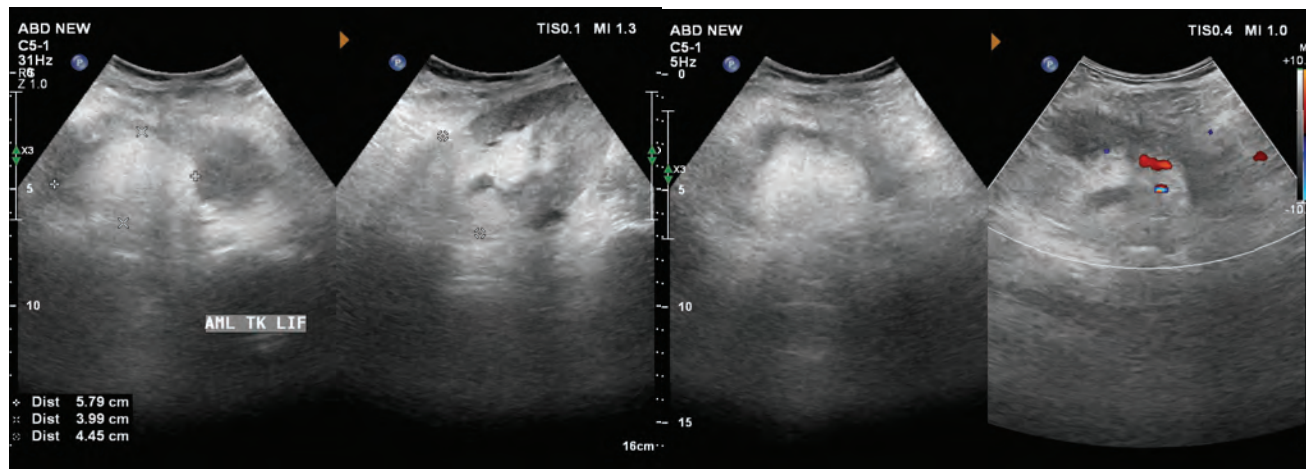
Ultrasound images of the transplant kidney showing an oval, echogenic, soft tissue lesion (left) with colour Doppler showing hypovascularity (right).
